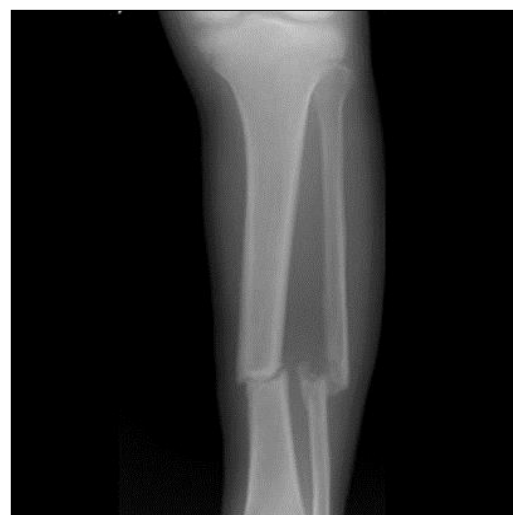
X-ray showing Non-Union Fracture Tibia and Fibula, six months post-injury.
